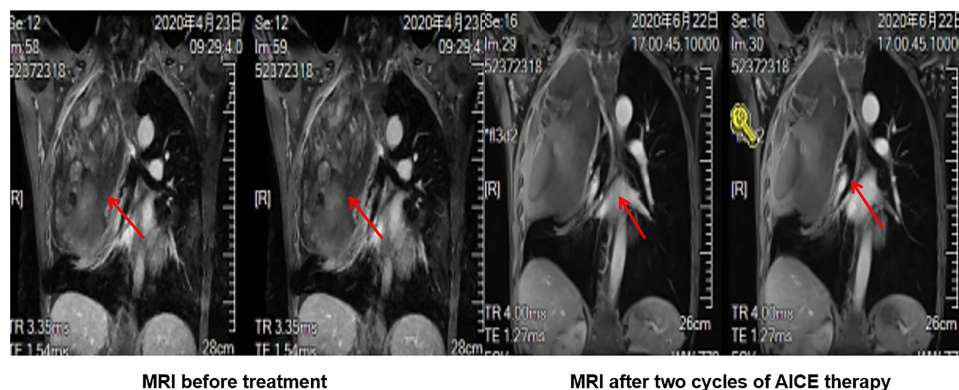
MRI scan results of the changes for target lesions in the thoracic cavity of a male patient with fibrosarcoma before and after the treatment of arterial infusion chemotherapy and embolization (AICE) (Red arrows: indicated the location of the treated hepatic lesion in pre- and post-treatment MRI images).
